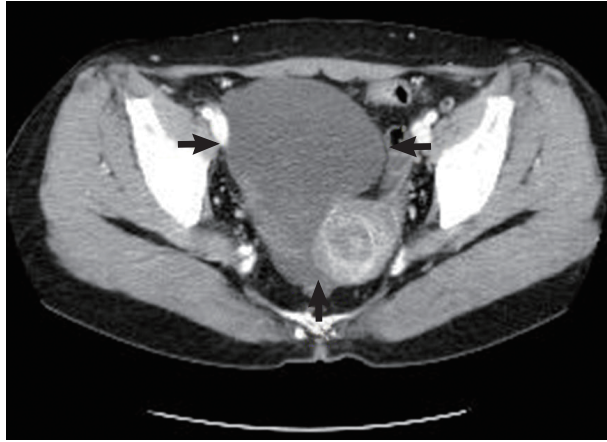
A pelvic computed tomography scan shows an 11 cm-sized lobulated cystic lesion (arrows) with a focally thick wall in the right adnexa.
